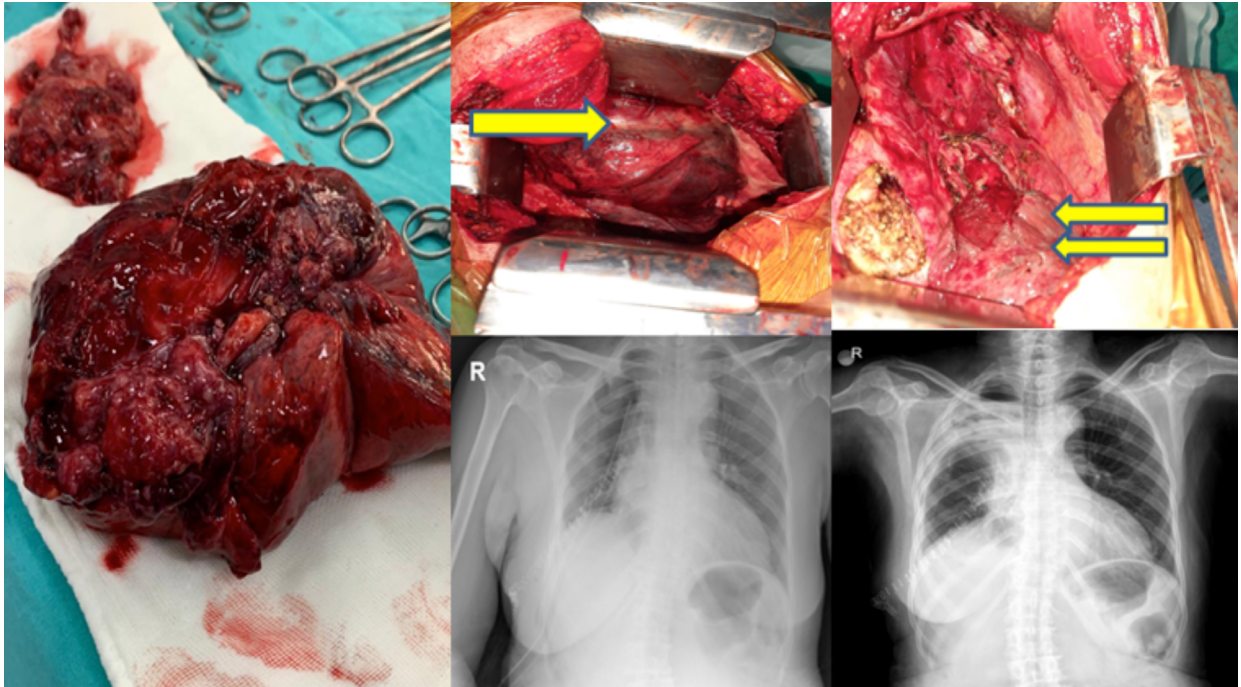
Perioperative images of the patient and pictures of the extracted piece and postoperative PA - lung X-rays. Single arrow: giant mass located in the upper lobe and middle lobe; double arrow: lower lobe.
